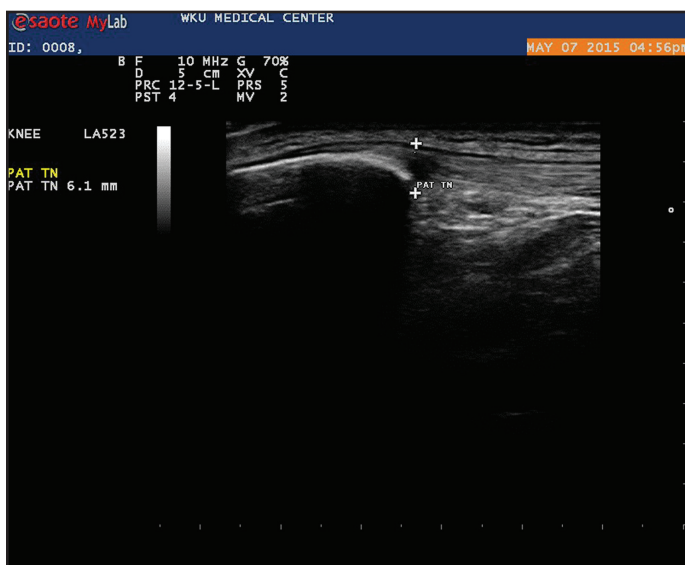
Ultrasound image of the pre-measured inferior pole of the patella.
